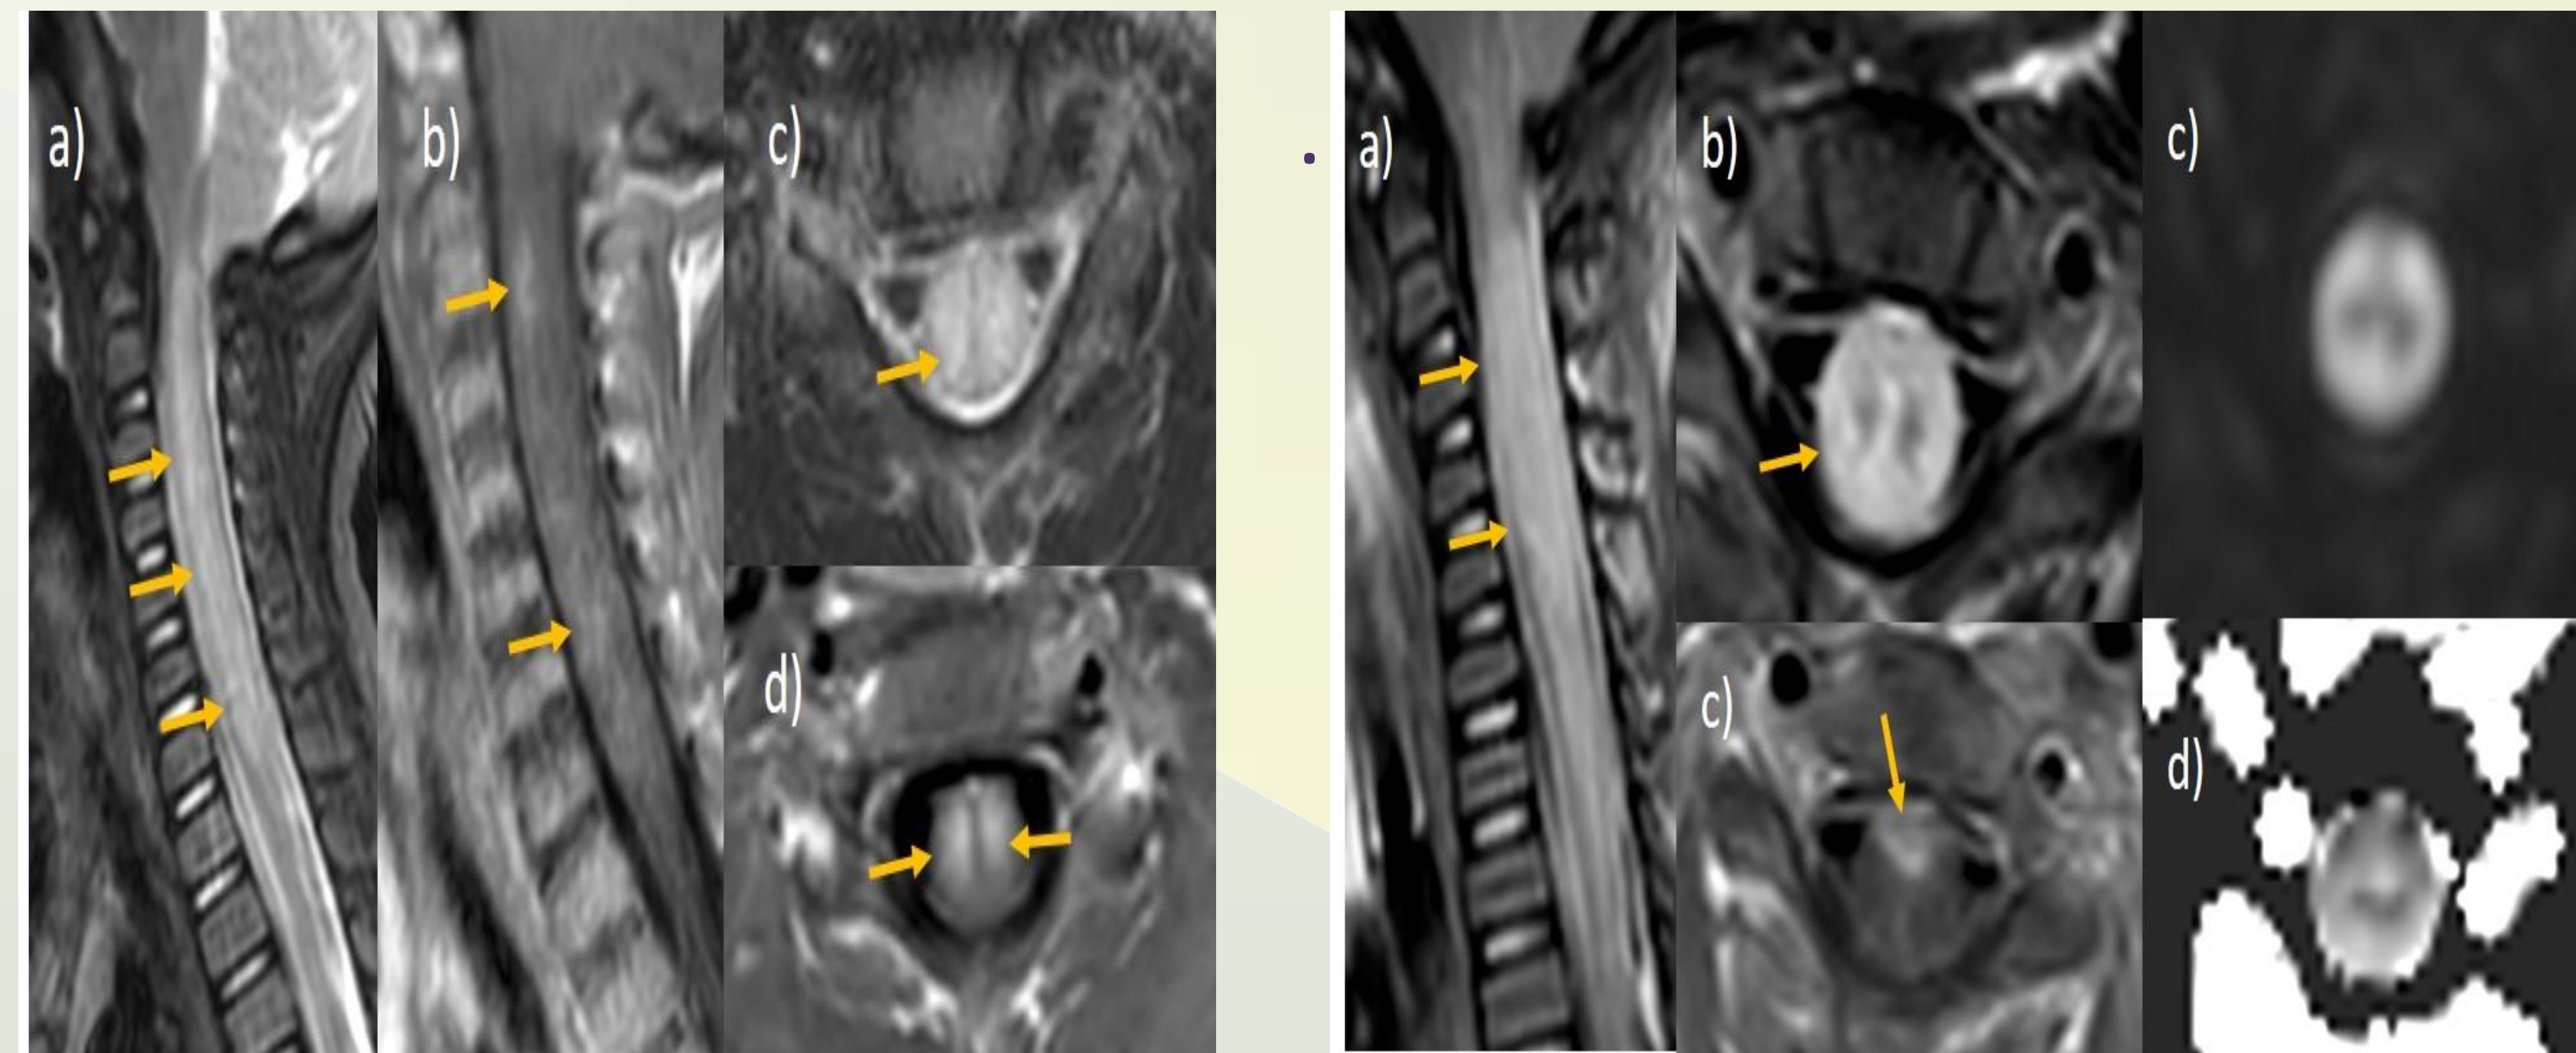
Sagittal STIR (a), post-contrast T1 (b), axial T2 (c) and post-contrast T1 (d) MRI showing extensive central cord T2 hyperintensity (a, c) with patchy intramedullary enhancement (b) centred around the central grey matter (d)
